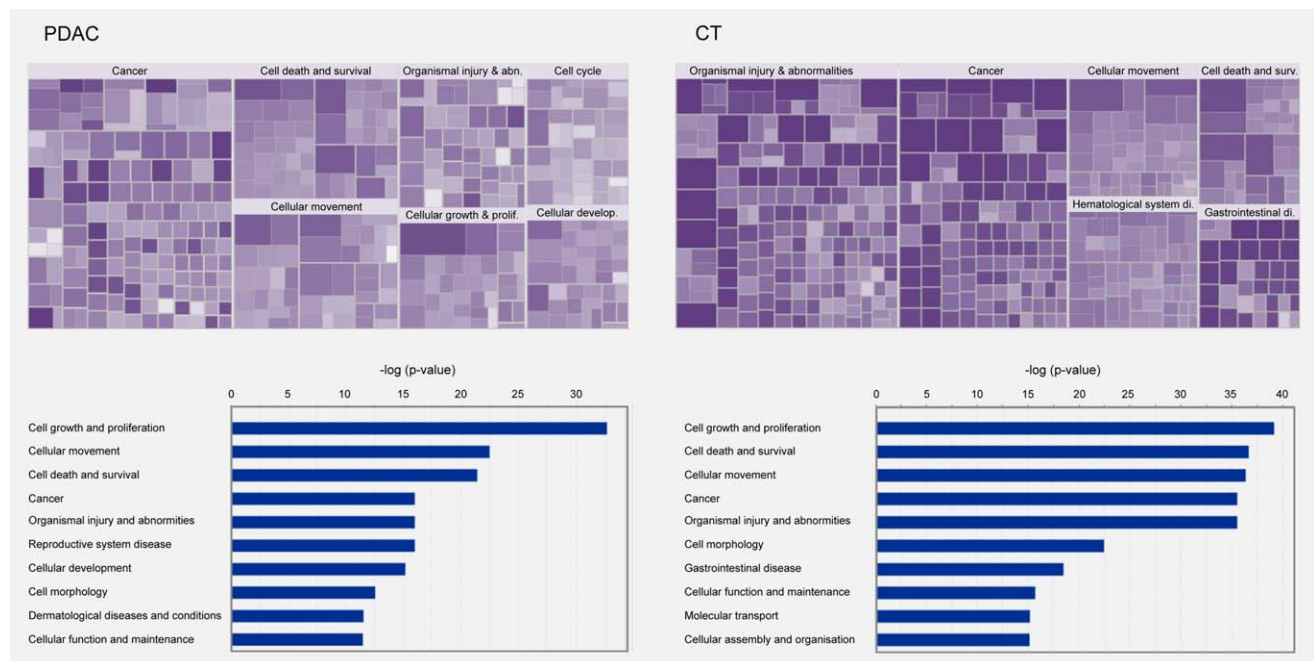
Most overrepresented biological functions associated with the 2,373 and 2,619 unique marker genes of PDAC and CT, respectively. Colour-coded maps of functional predictions resulting from an Ingenuity Pathway Analysis are shown. Each rectangle represents one function. The intensity of the purple colour of a square is proportional to the number of genes that are associated with the respective function. The size of a square reflects the associated negative \log_{10} of the assigned p values. Larger squares indicate a more significant overlap between the genes perturbed in the dataset and the respective function. The top 10 biological functions were ordered in a bar blot according to their significance by the negative \log_{10} of the assigned p values. The complete lists can be found at Supporting Information Fig. 6.
